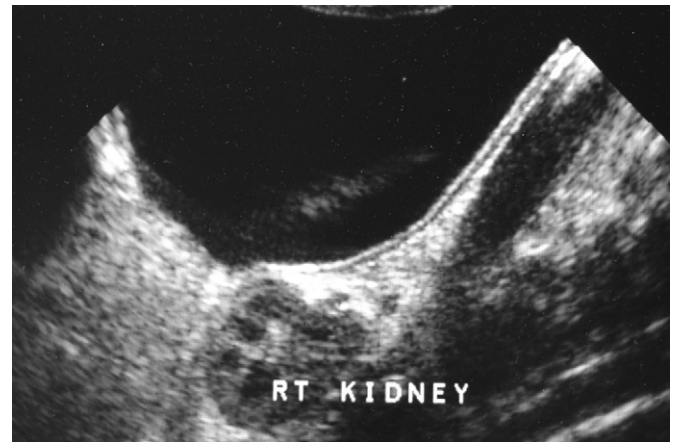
Ultrasound study of an ileal duplication shows the characteristic echogenic signal of the mucosal lining.
